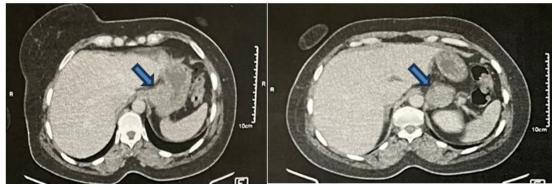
Axial slide of abdominal CT scan showing the process
